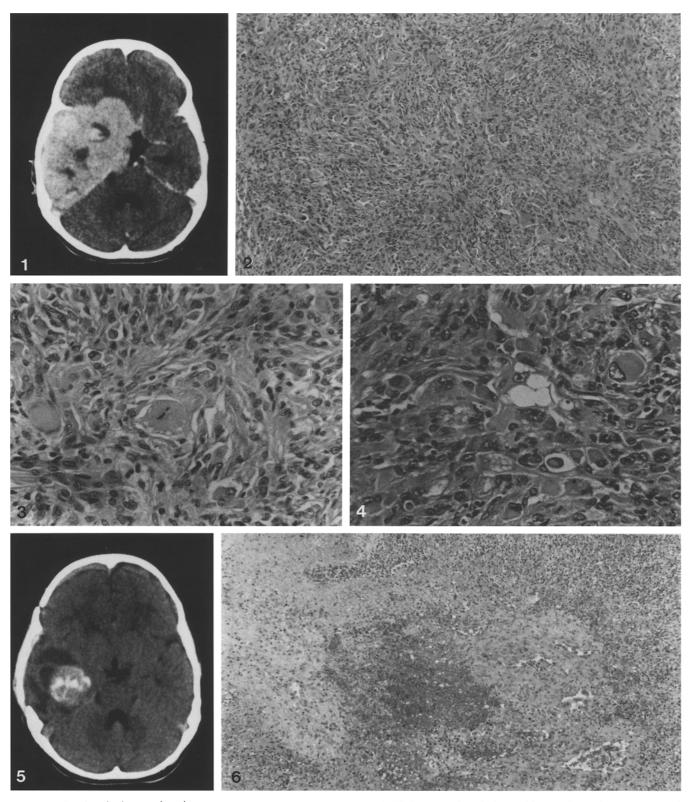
CT showing the large enhancing tumor
